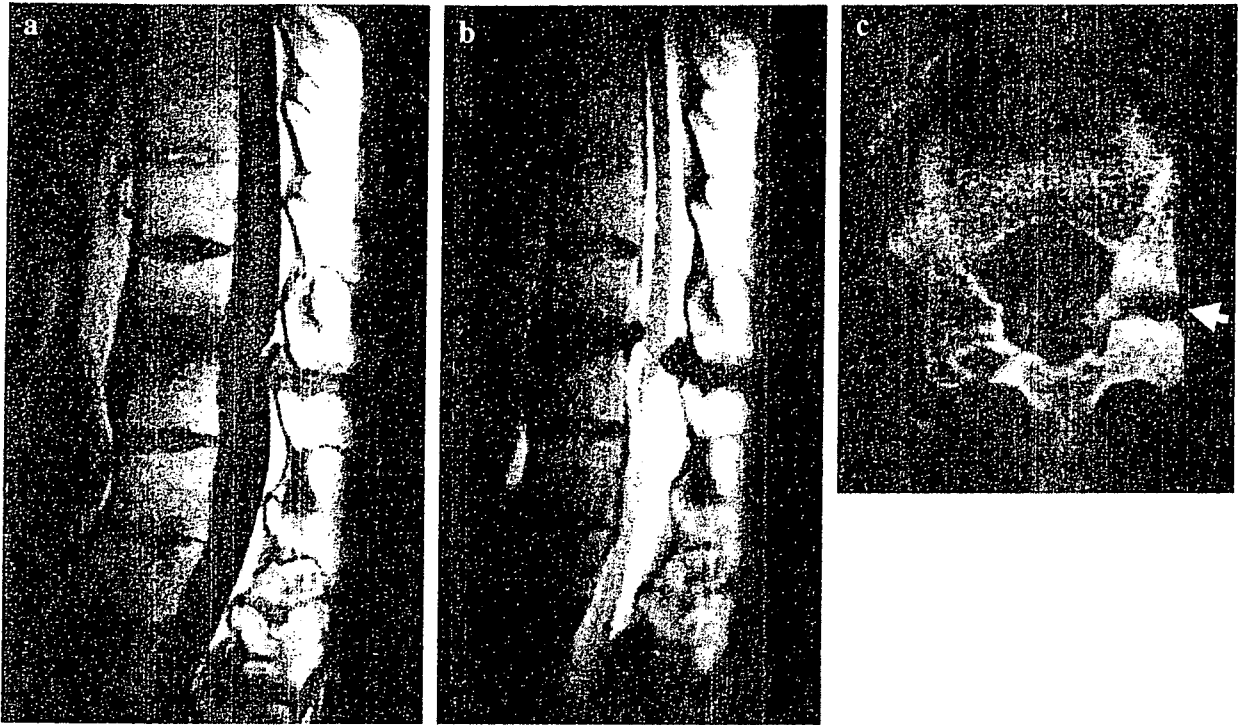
Before surgery, magnetic resonance imaging showed decreased signal intensity at the disc space and the adjacent margins between T11 and T12 on both the (a) T1- and (b) T2-weighted images. The dural sac was compressed by the protruding disc and the hypertrophied yellow ligaments. (c) Computed tomogram showed a fracture of the left pars interarticularis at T12 (arrow) and calcification of the hypertrophied yellow ligaments.
